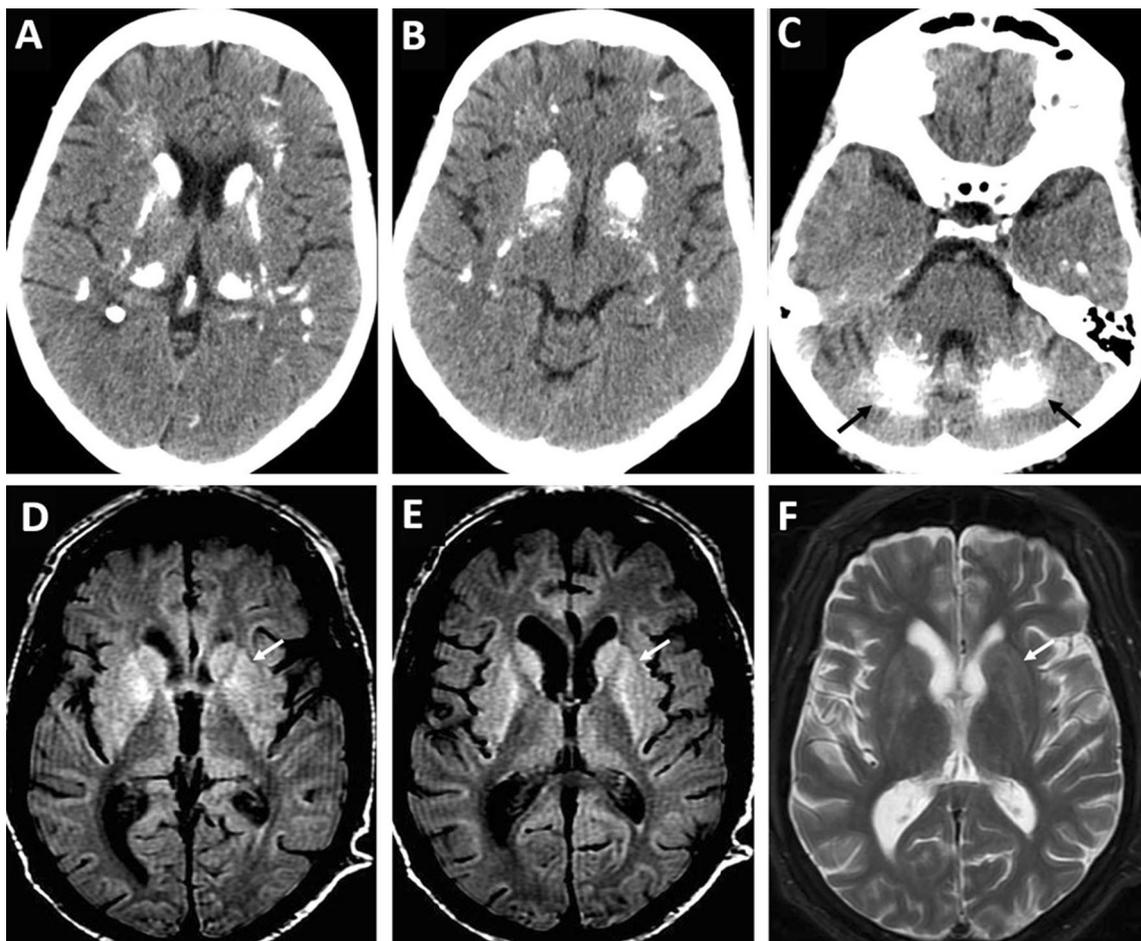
Neuroimaging of selected metabolic disorders (1/2). Diffuse bilateral calcification in the basal ganglia, thalamus (a, b), and dentate nucleus (c) on head CT in patient with primary hypoparathyroidism. Courtesy of Dr. Miryam Carecchio, Department of Neuroscience, University of Padua, Padua, Italy. Extrapontine myelinolysis. Axial
